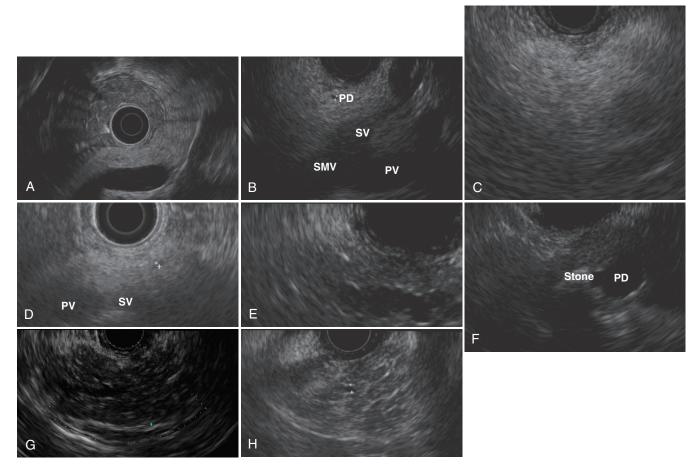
EUS views of normal pancreas versus chronic pancreatitis. A, Normal pancreas: electronic radial EUS. B, Normal pancreas: linear EUS. PD, pancreatic duct; PV, portal vein; SMV, superior mesenteric vein; SV, splenic vein. C and D, Fatty/snowstorm body of pancreas (BOP) on linear EUS (C) and electronic radial EUS (D): splenic artery and SV and PV blurry and barely discernible because of marked attenuation by the pancreas above them; a duct is difficult to see. E, Linear EUS of an irregular PD in BOP. F, Obstructing stone in the PD in the head of the pancreas on linear EUS, with a wedge of acoustic shadowing and upstream PD dilation. G, Dilated side branch (*thin arrow*) with small power Color Doppler–positive vessels mimick-ing branches in BOP on linear EUS. H, Hypoechoic (dark) lobules (*) surrounded by bright hyperechoic strands, with an echogenic duct wall (+ calipers) in BOP on linear EUS.
